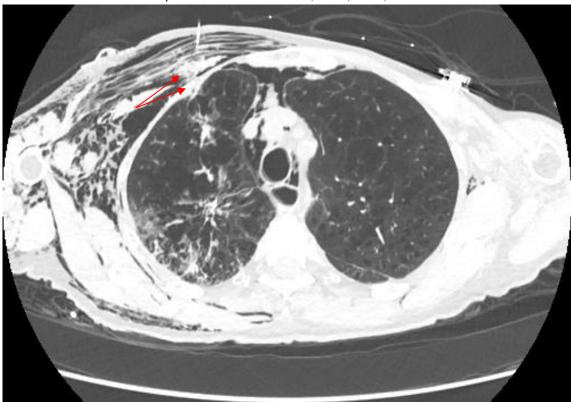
Axial CT scan after the fibrin injection showing narrowing of the pleural tract, the presence of fibrin material within the tract [lower arrow], and presence of a large subcutaneous fibrin plug superficial to the pleural tract [upper arrow].
